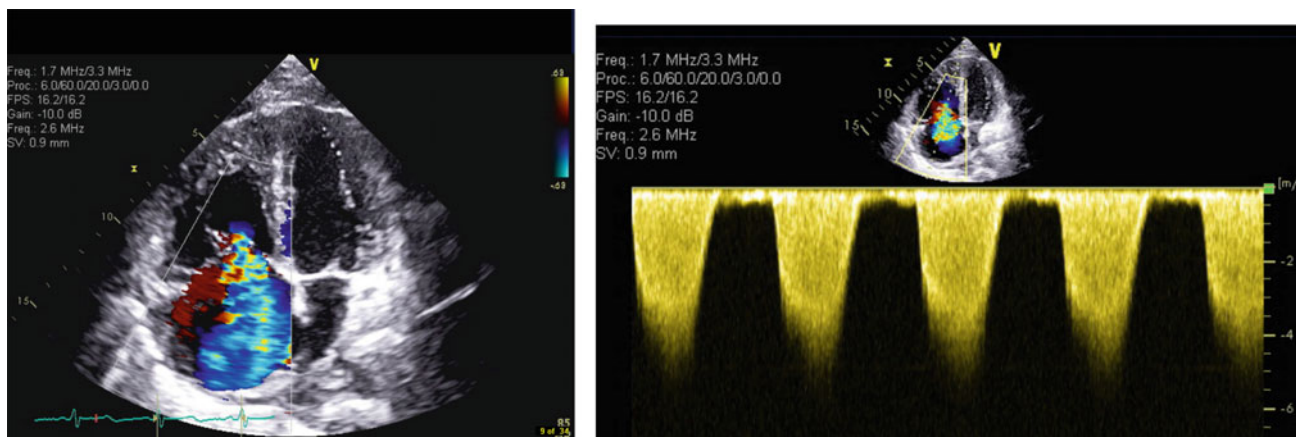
Color (left) and continuous wave (right) Doppler of severe tricuspid regurgitation in a case of severe pulmonary hypertension attributable to BCR-ABL TKI therapy
